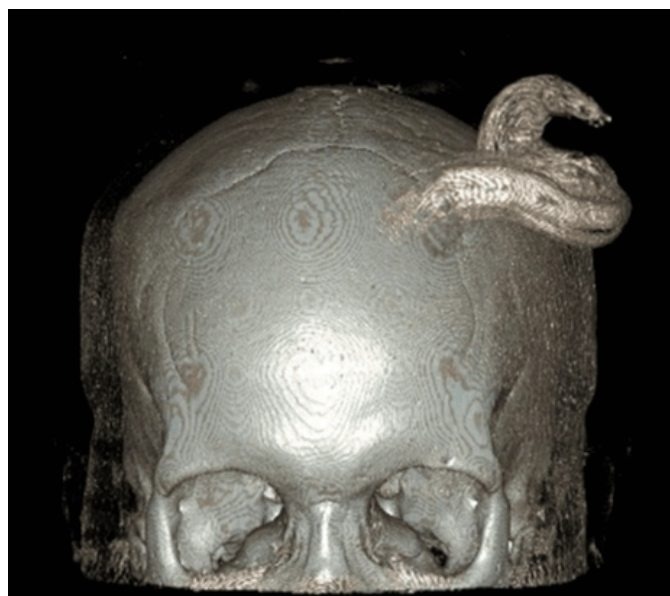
Computed tomography scan, 3-D reconstruction.
